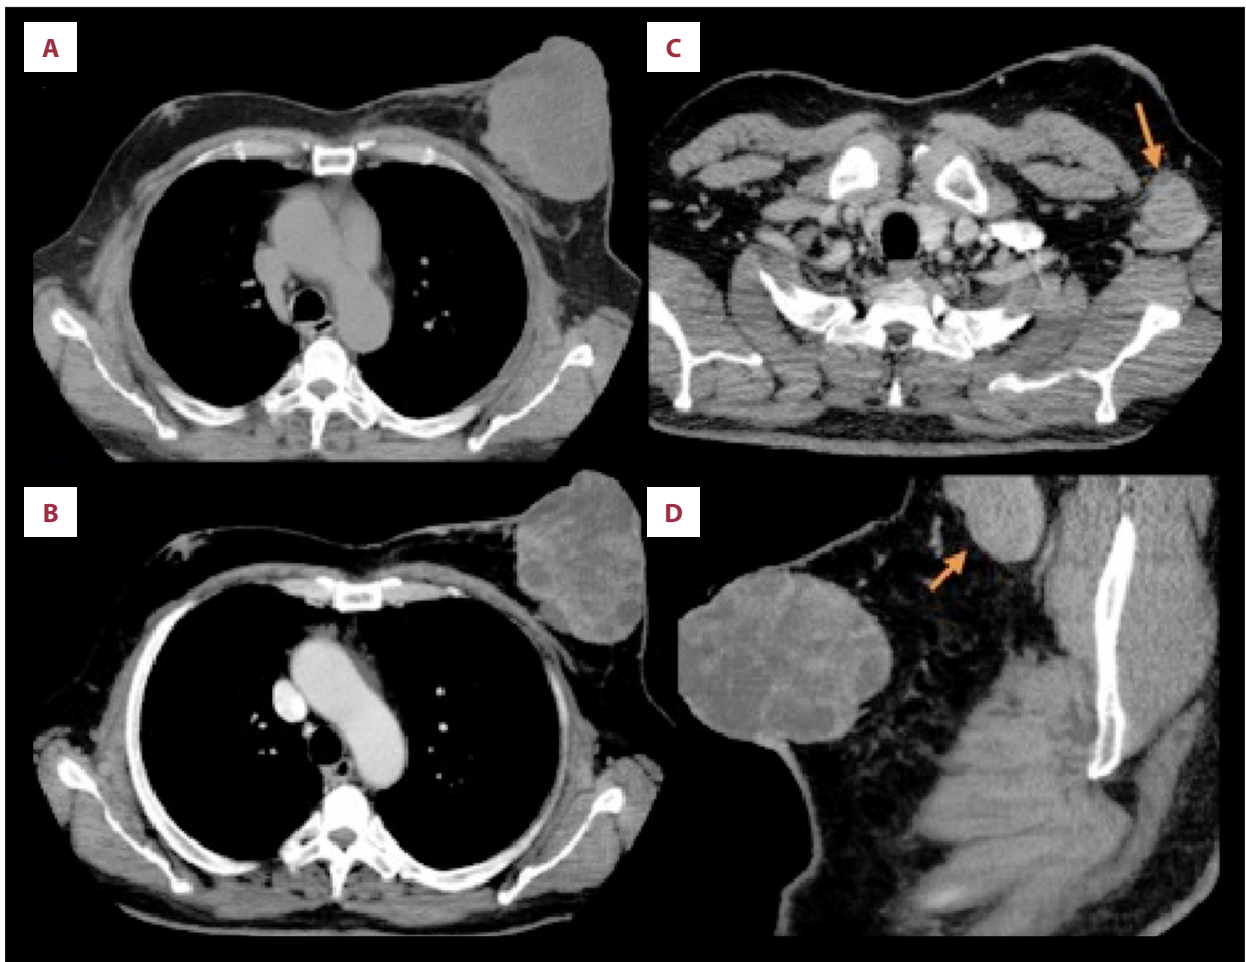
Computed tomography (CT) imaging of the left breast and axilla (A) Axial non-enhanced computed tomography (CT) imaging. (B) Axial enhanced computed tomography (CT) imaging shows a heterogeneous and necrotic exophytic mass in the left breast associated with thickening of the skin with a preserved fat plane between the mass and underlying pectoralis muscle. (C) Axial and (D) sagittal views show an enlarged ipsilateral axillary lymph node (arrows).
